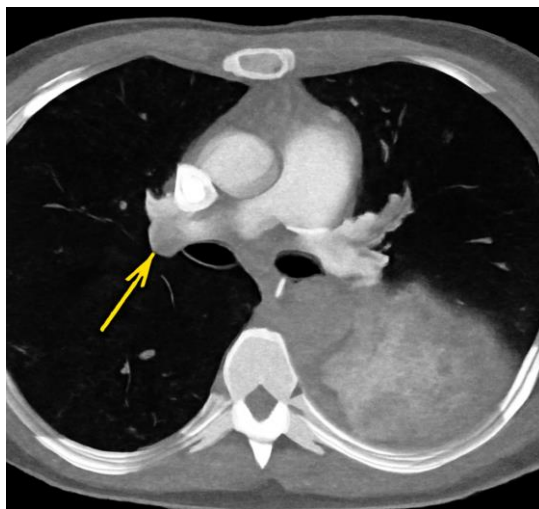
CT Pulmonary Angiography Showing Peripheral Pulmonary Embolism with Ground-Glass Opacities Mimicking Pneumonia
